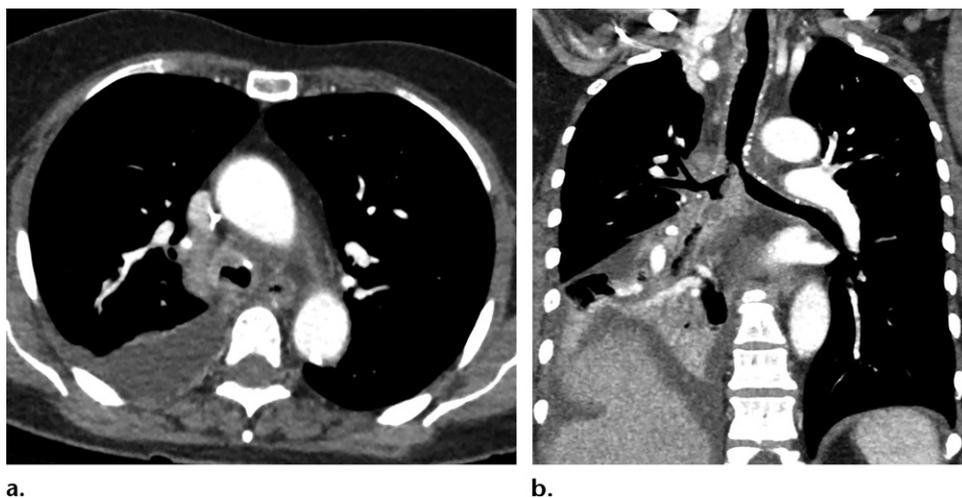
Endobronchial mucormycosis. (a) Axial CT image shows soft-tissue thickening of the lateral and anterior trachea with ill definition of the surrounding fat. (b) Coronal multiplanar curved reconstruction from CT of the tracheobronchial tree shows extensive soft tissue in and around the carina and right main bronchi, with occlusion of the bronchus intermedius and right lower lobe collapse. (Case courtesy of Cameron Hassani, MD, University of California, Los Angeles, Los Angeles, Calif.)
